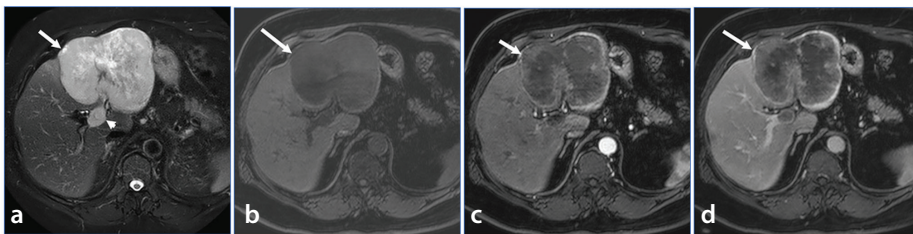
Extrapulmonary small cell carcinoma. Axial T2-weighted magnetic resonance imaging (MRI) with fat suppression (a) and pre-contrast (b) and dynamic post-gadolinium T1-weighted MRI with fat suppression in the arterial (c) and portal venous (d) phases show an extrapulmonary small cell carcinoma of the left hepatic lobe (white arrows) demonstrating high T2 signal intensity, low T1 signal intensity, and intense peripheral enhancement and poor central enhancement, with invasion of the left portal vein (short white arrow).
